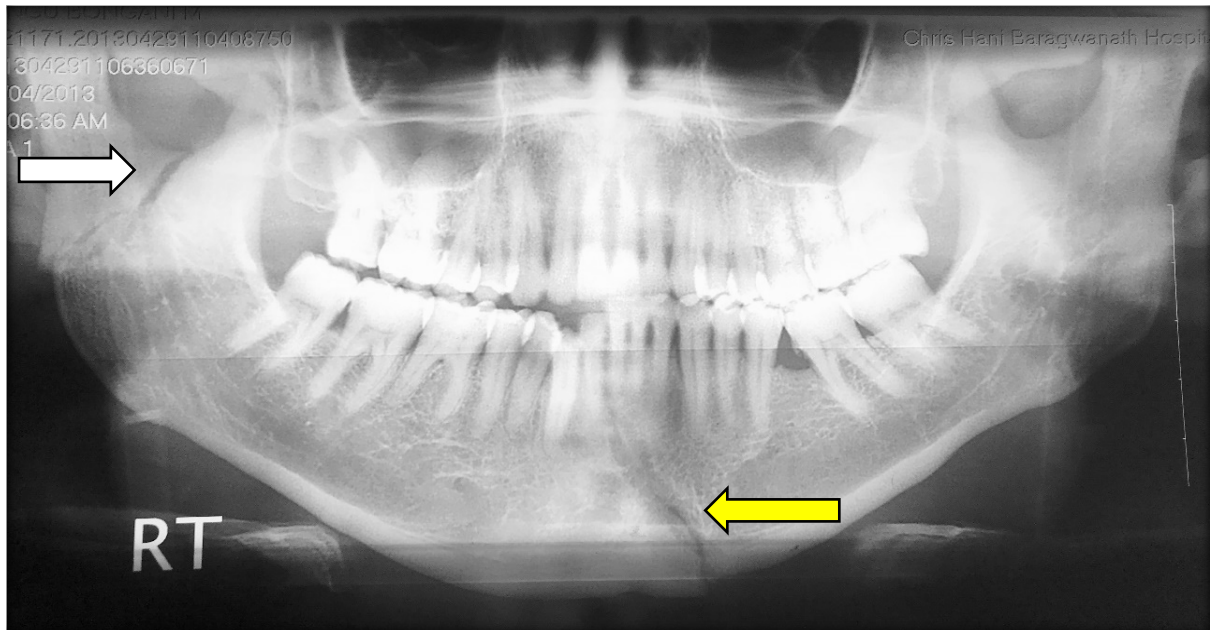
Preoperative panoramic X-ray showing Type II B fracture (white arrow) and symphyseal fracture (yellow arrow).
